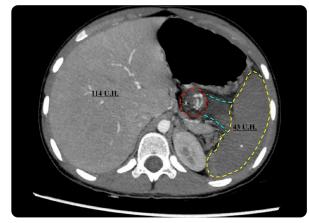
CT portal phase. The distal end of the tail of the pancreas is seen included in the torsion focus (X), the spleen remains hypodense in relation to the liver. Video of tomography in the following link: https://www.youtube.com/watch?v=4PXeyvWbNvg
